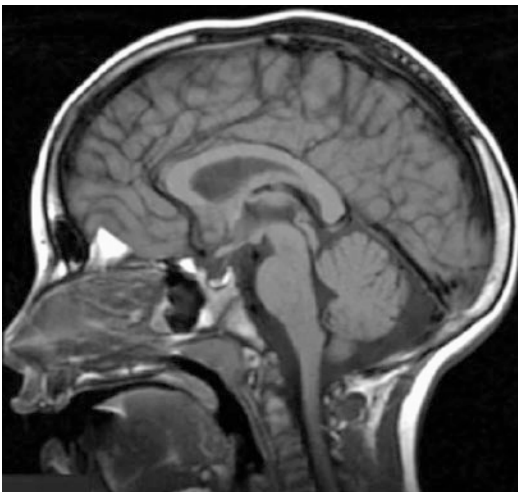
Normal T1 sagittal MRI of a 5-year-old
